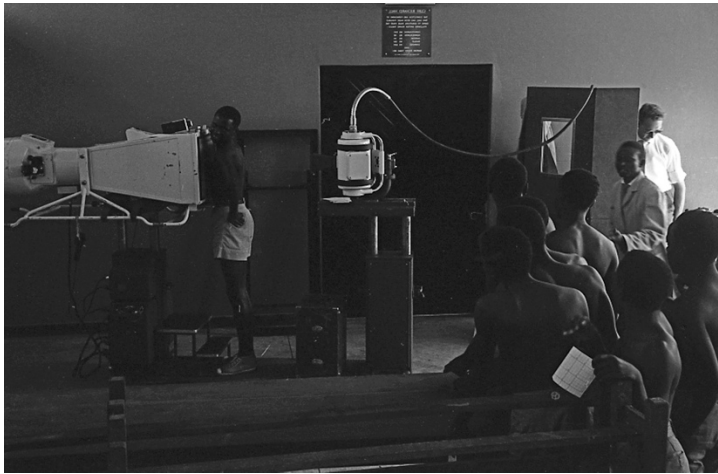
“Mass examination of the children in a school in Nairobi, Kenya. The children are registered, then X-rayed.” 1964, HQ31035, WHO Photo Library.
